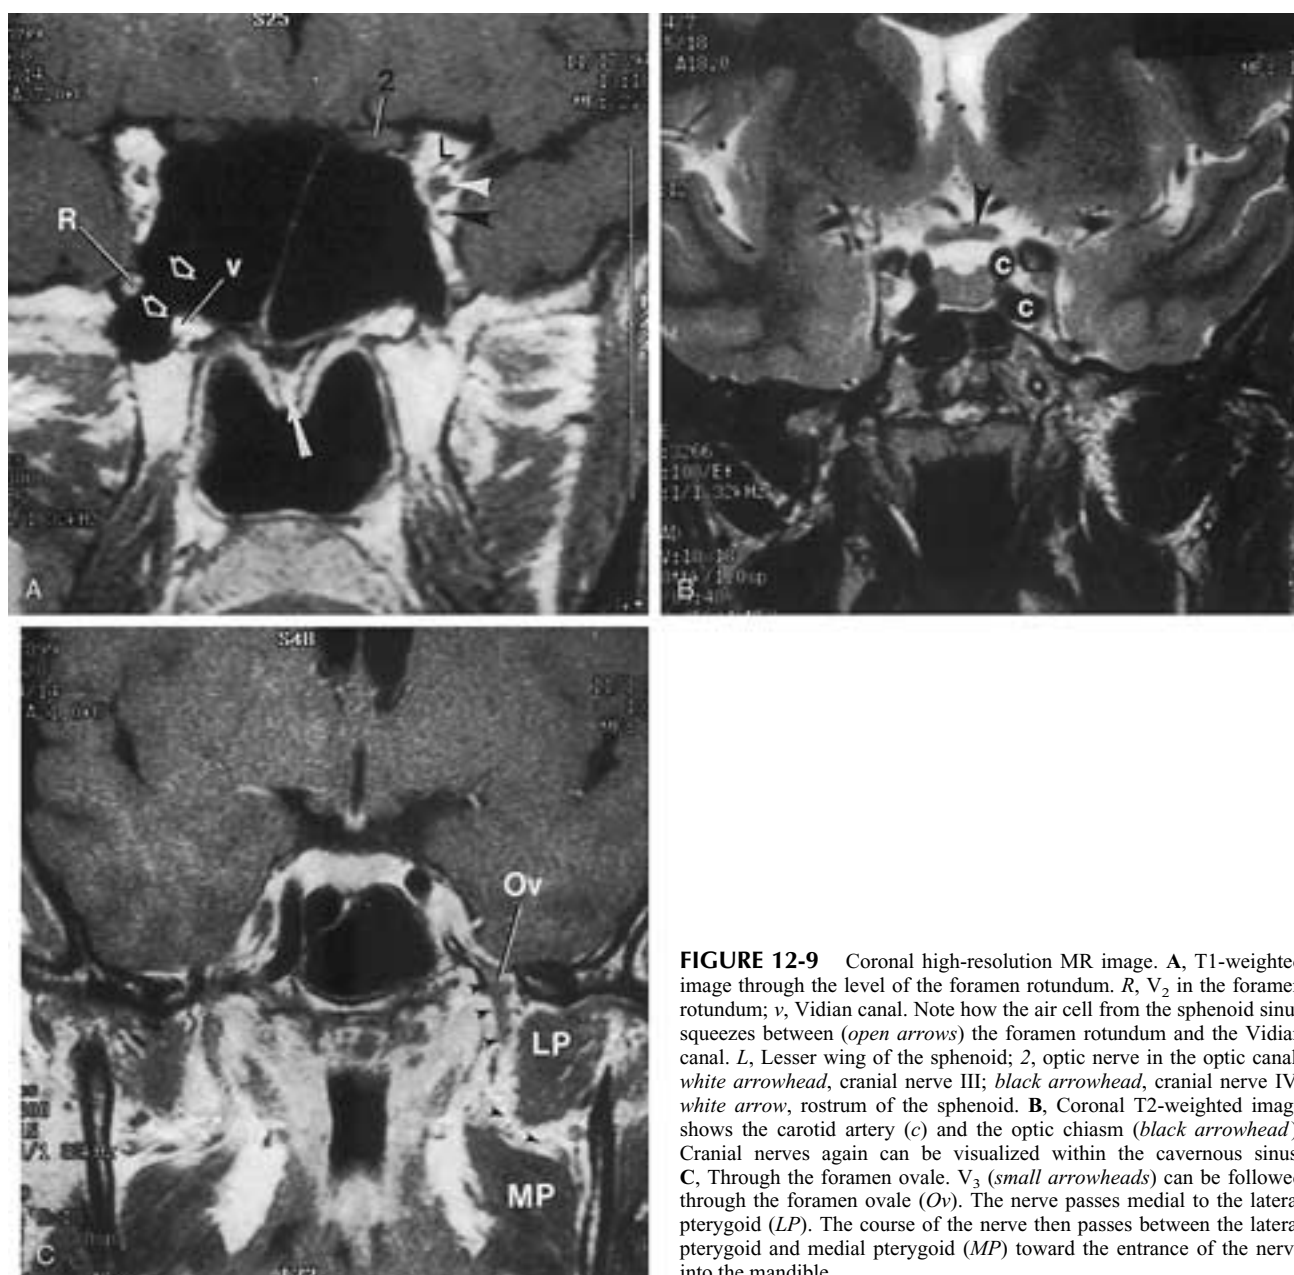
Coronal high-resolution MR image. A, T1-weighted image through the level of the foramen rotundum. *R*, *V₂* in the foramen rotundum; *v*, Vidian canal. Note how the air cell from the sphenoid sinus squeezes between (*open arrows*) the foramen rotundum and the Vidian canal. *L*, Lesser wing of the sphenoid; *2*, optic nerve in the optic canal; *white arrowhead*, cranial nerve III; *black arrowhead*, cranial nerve IV; *white arrow*, rostrum of the sphenoid. B, Coronal T2-weighted image shows the carotid artery (*c*) and the optic chiasm (*black arrowhead*). Cranial nerves again can be visualized within the cavernous sinus. C, Through the foramen ovale. *V₃* (*small arrowheads*) can be followed through the foramen ovale (*Ov*). The nerve passes medial to the lateral pterygoid (*LP*). The course of the nerve then passes between the lateral pterygoid and medial pterygoid (*MP*) toward the entrance of the nerve into the mandible.
